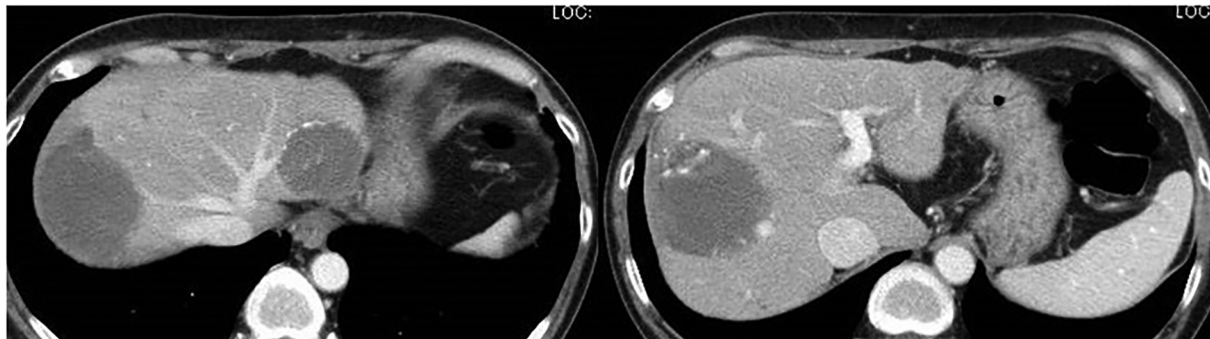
CT images after multimodal therapy.
